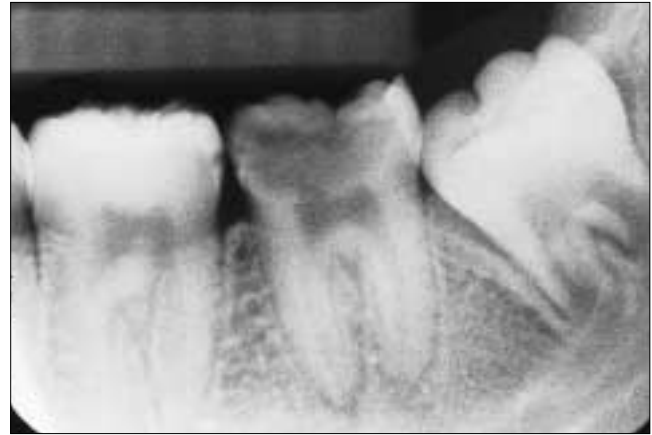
Periapical radiograph of the left posterior mandible demonstrating extensive decay associated with tooth 37. Note the stage of root development of tooth 38.
